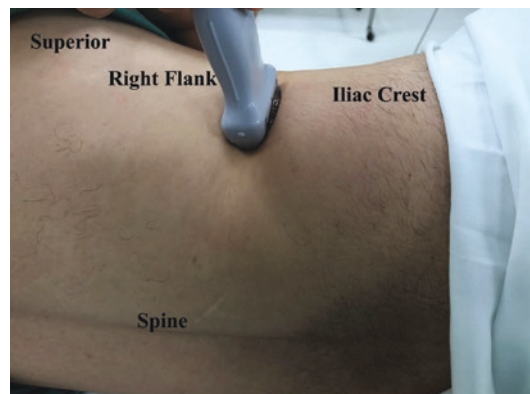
The patient is placed in the left lateral decubitus position. Ultrasound probe placed on the flank to evaluate for hernia
